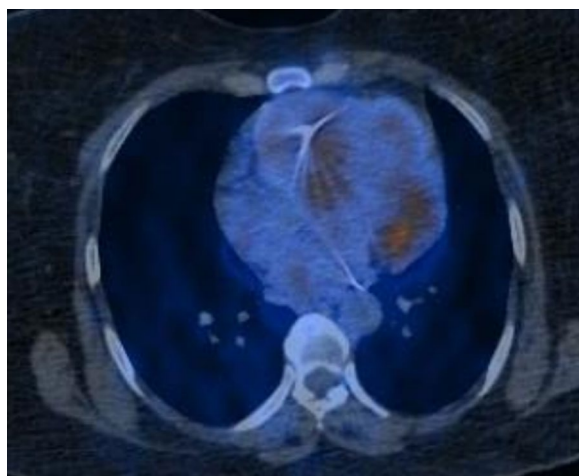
PET CT fusion image showing dilated left ventricle with patchy increased metabolic activity is seen in the wall of the left ventricle (SUV max = 8)
